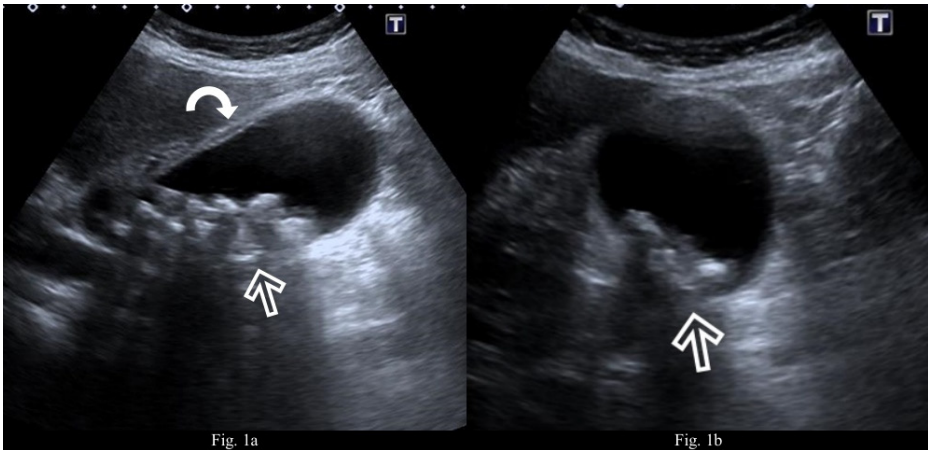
Ultrasonography images of a patient with acute cholecystitis show (a), (b) multiple stones with posterior acoustic shadows in the gallbladder (hollow arrows) and (a) thickening of the wall (curved arrow) and an increase in the diameter of the gallbladder.
